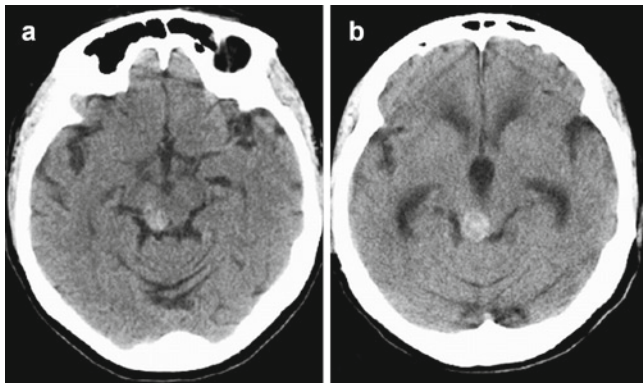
Cavernoma of the lamina quadrigemina. Axial CT at the time of diagnosis (a) and after 8 months (b). Calcifications in the right superior colliculus (a) and enlargement of the hyperdense region due to bleeding with compression of the aqueduct and CSF accumulation (b)
